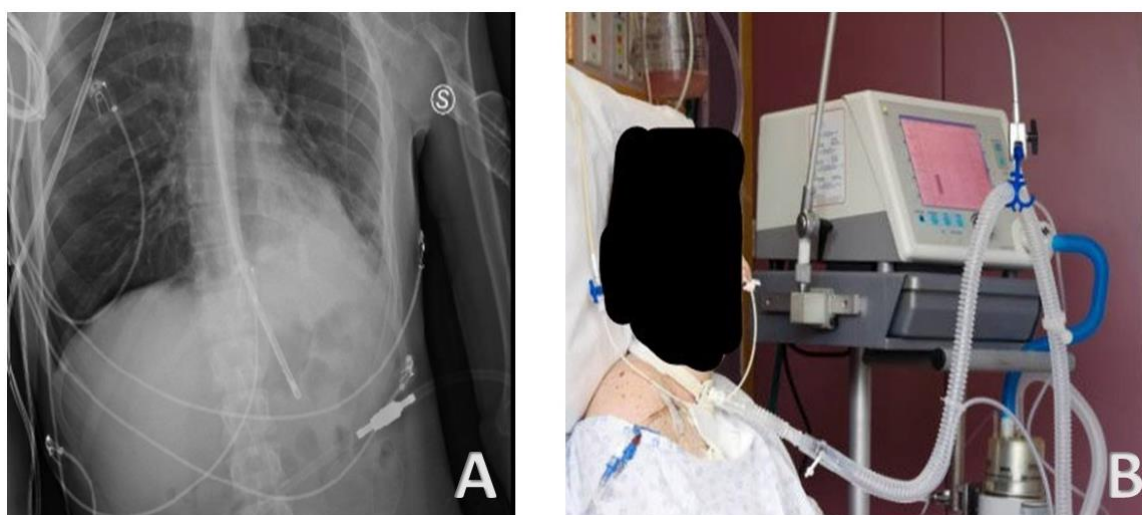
(A) Radiological picture of a bedside chest x-ray; (B) Mechanical ventilation system connected to the tracheostomy. The respiratory assistance technique is described for the patient who has been taken into care. For further clinical implications, see also the main text of the described clinical case.
